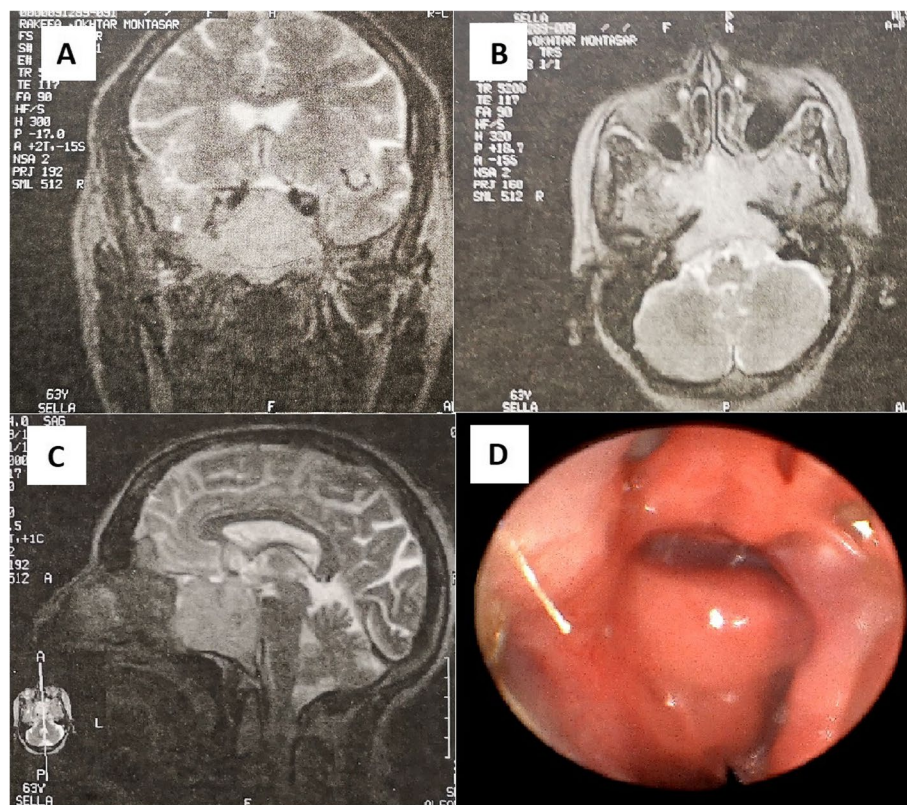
A 63-year-old female patient with a petroclival chordoma: A coronal T2 MRI image, B axial T2 MRI image, and C sagittal T2 MRI image showing a large clival lesion intermediate to hyperintense signal with invasion of the sella with right parasellar extension and extension to sphenoidal sinus and both pterygoid plates and prepontine cistern posteriorly. D A 3-month postoperative endoscopic view showing the healed nasoseptal flap covering the skull base defect
